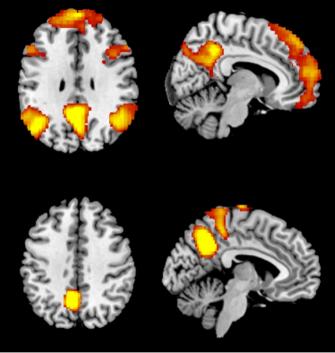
Resting state functional MR images showing normal (top) and abnormal (bottom) default-mode network in individuals with impaired consciousness. From [26], Copyright © 2017 Springer Science+Business Media New York.
